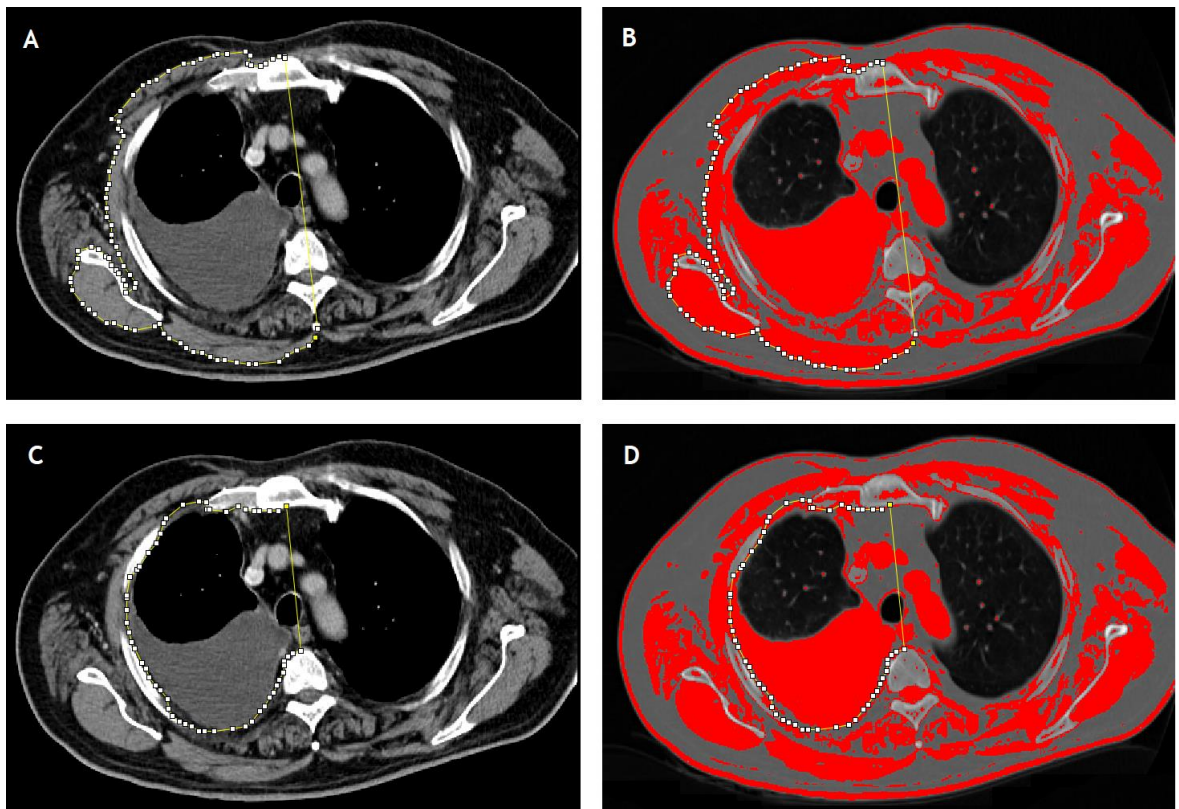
Axial slices of CT scans demonstrating fourth thoracic vertebra (T4). Panel A demonstrates the delineation of the external skeletal muscle area (SMA) on the ipsilateral side of MPM tumour, defined by the area included in the dotted yellow line. Note the straight yellow line separating the ipsilateral and contralateral muscle compartments. Panel B demonstrates the skeletal muscle threshold selection (HU range, -29 to +150 HU). Panel C demonstrates the delineation of internal SMA, defined by the area included in the dotted yellow line. Panel D demonstrates skeletal muscle HU threshold selection
